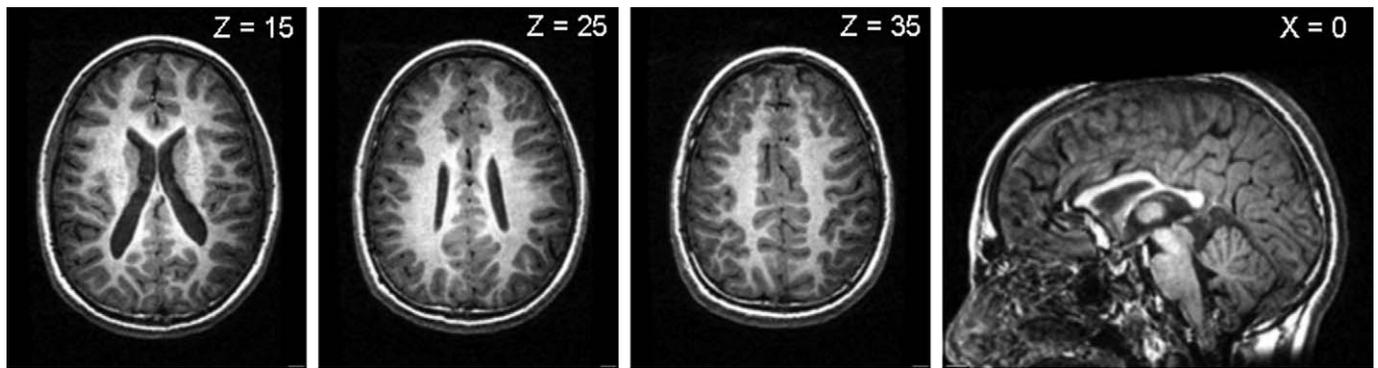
Three axial slices and 1 sagittal slice from the T1-weighted magnetic resonance imaging scan of the participant born prematurely.
